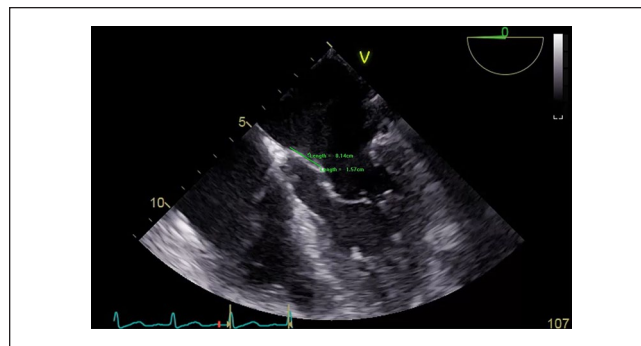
Transesophageal echocardiogram revealed a 0.14 cm × 1.57 cm vegetation on the atrial side of the anterior mitral valve.
